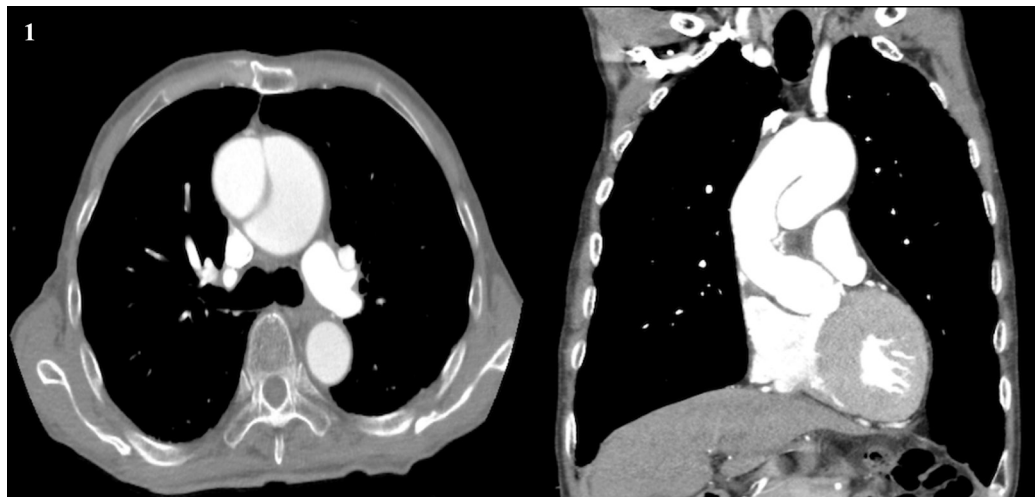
Preoperative contrast-enhanced computed tomography showing DeBakey type II aortic dissection with a diameter of 60 mm.
